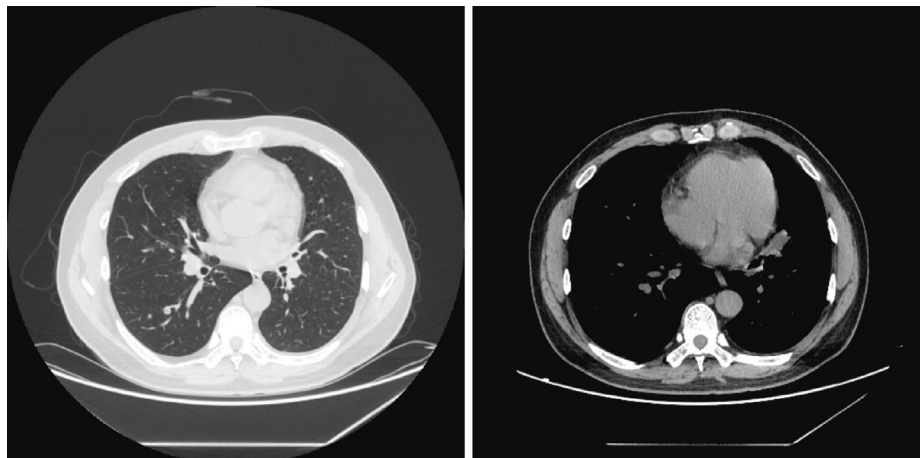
Chest computed tomography (CT) and follow-up CT images. (a) A lesion in the left upper lung with small diffuse bilateral pulmonary nodules and mediastinal lymphadenopathy before treatment. (b) Although the lesion in the left upper lung was stable, the size and number of small diffuse bilateral pulmonary nodules after two cycles of pembrolizumab plus chemotherapy had increased. (c) There was a further reduction in size and number of bilateral pulmonary nodules after three cycles of pembrolizumab plus chemotherapy. (d) Chest CT in March 2021 showed an increase in size of the lesion in the left upper lung
